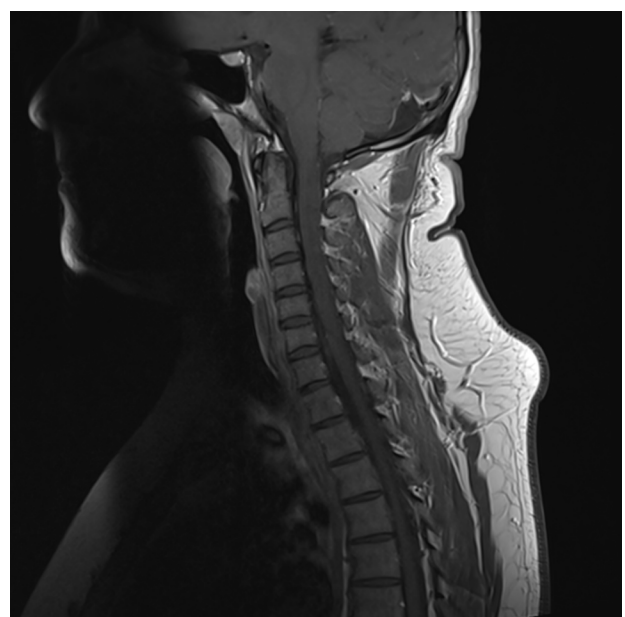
Sagittal T1-weighted contrast-enhanced image of the cervical spine showing no zones of focal enhancement
